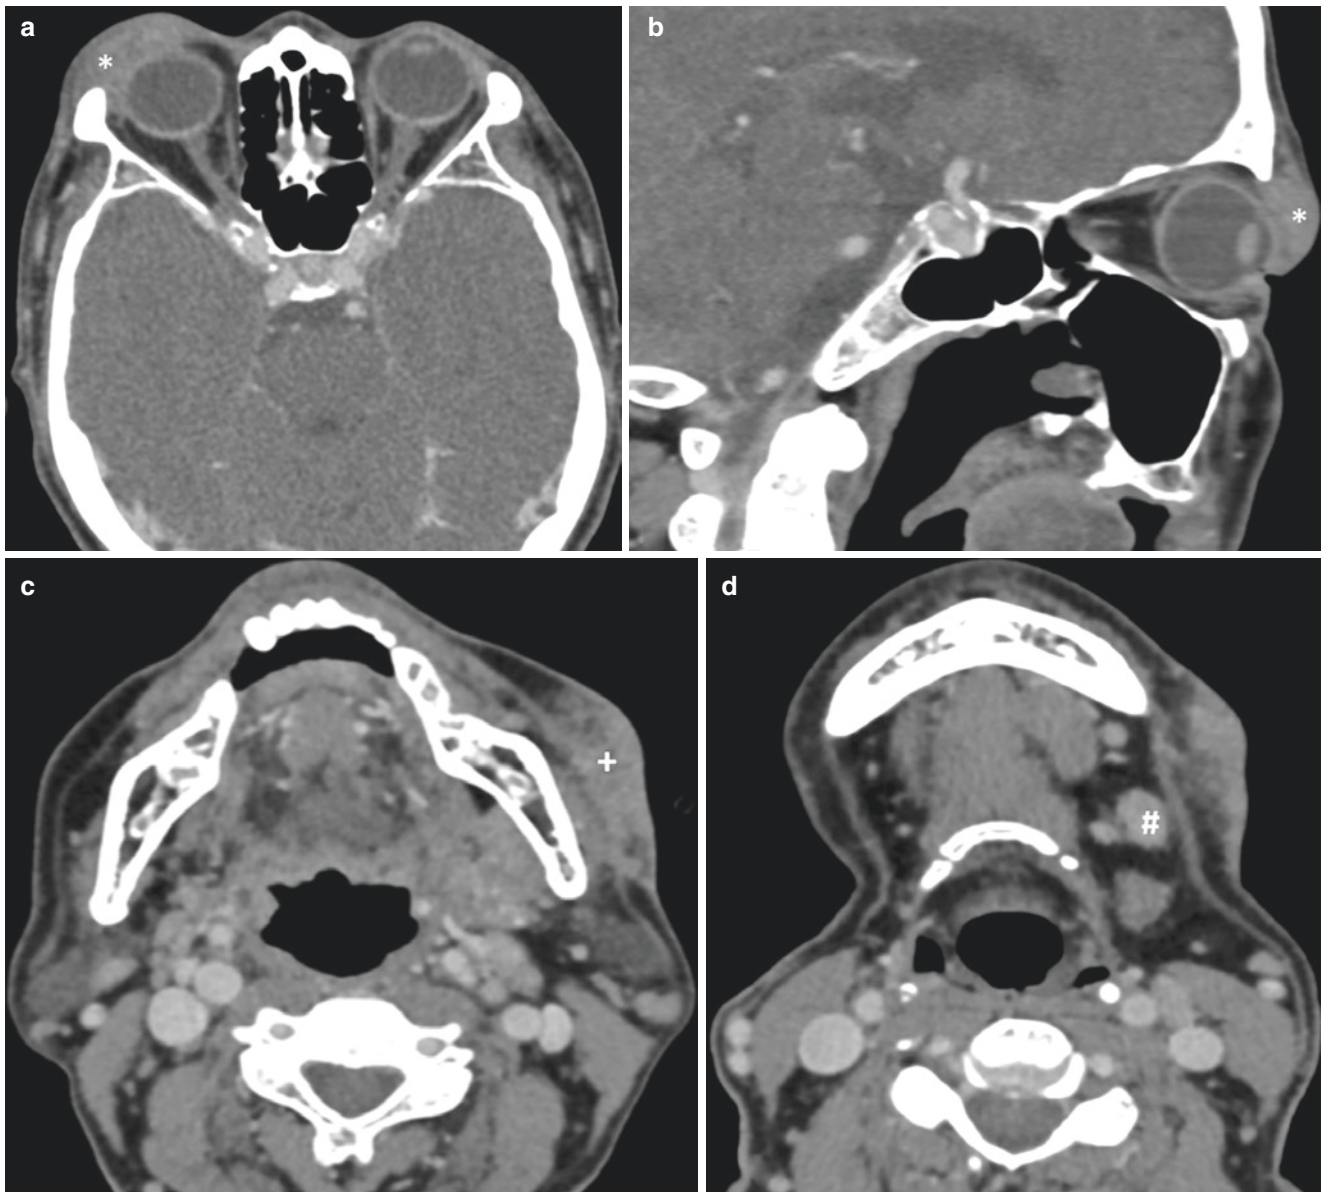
Case 2: (a, b) CT-axial and sagittal scans showing the preseptal mass in the right upper lid (*). (c) Axial CT scan showing left parotid mass (+). (d) Axial CT scan showing left enlarged submandibular gland (#)
